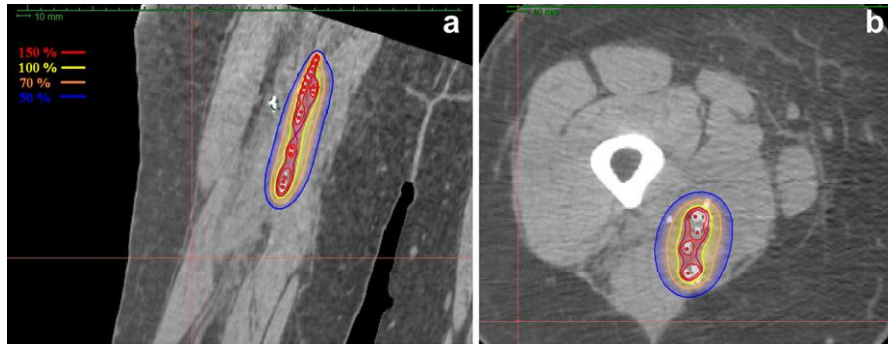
Three-dimensional CT-based dosimetry of a brachytherapy implant as seen in (a) coronal and (b) axial planes. The 150–50% isodoses are demonstrated. (b) Surgical clips help to delineate the clinical target volume.
